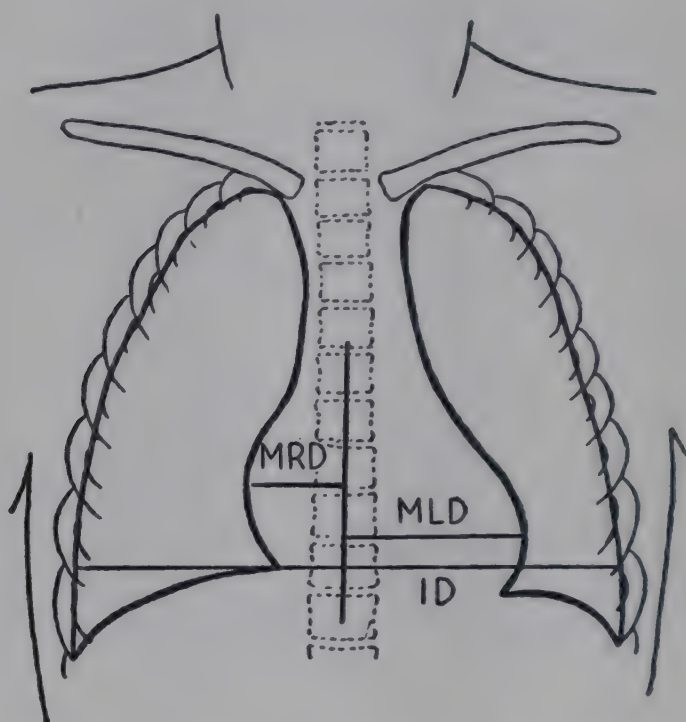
Cardiac roentgenology: method for obtaining measurements of the cardiothoracic index from a teleroentgenogram. See text for details. (From Caffey, J.: *Pediatric X-Ray Diagnosis* [2d ed.; Chicago: Year Book Publishers, Inc., 1950].)
